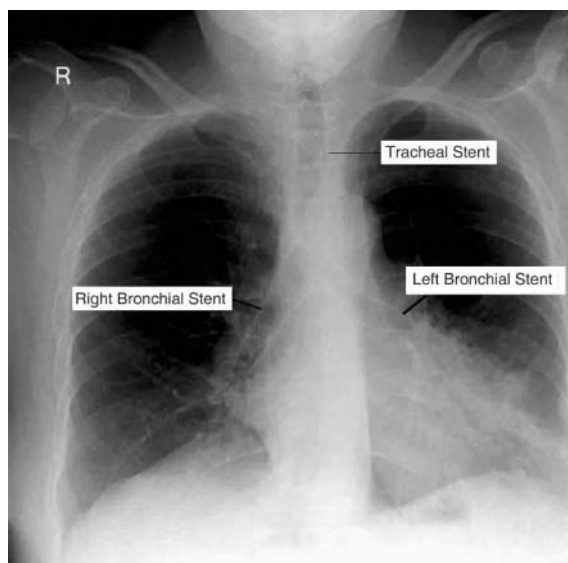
The chest X-ray shows the same patient as in Fig. 1, following surgery and the insertion of a tracheal stent and right and left bronchial stents.
